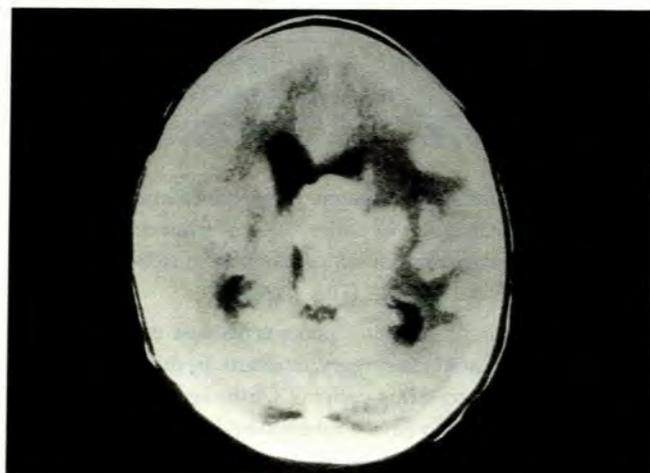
Mass on this CT scan found to be a tuberculoma.
